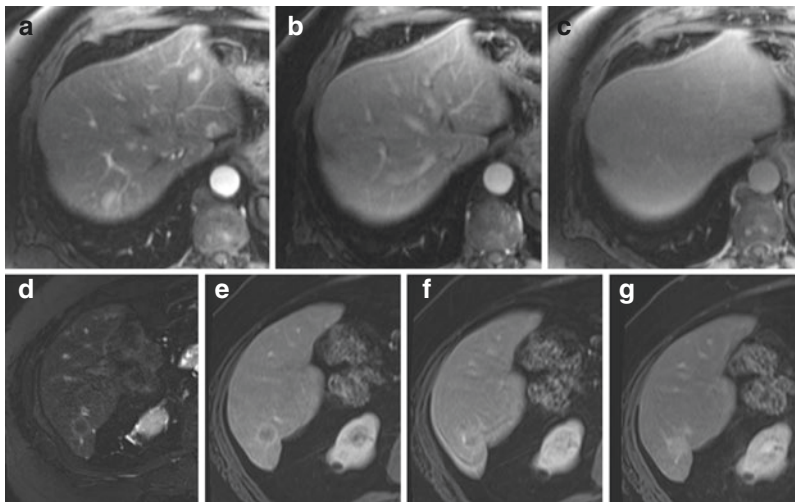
Hemangiomas, atypical appearance. MRI of the liver in a patient with multiple vertebral body and splenic hemangiomas shows an avidly arterially enhancing focus (a) which is isointense to liver parenchyma on other phases (b, c). Several other lesions with similar enhancement pattern were seen throughout the liver, compatible with flash filling hemangiomas. MR images from a patient being followed up after renal mass ablation demonstrate a lesion in the posterior right hepatic lobe with a rim of T2 hyperintensity and a hypointense core (d) as well as rim-like arterial enhancement (e) with progressive central fill-in on delayed (f, g) phase images. This finding was stable for greater than 4 years and therefore compatible with a partially sclerosed hemangioma
